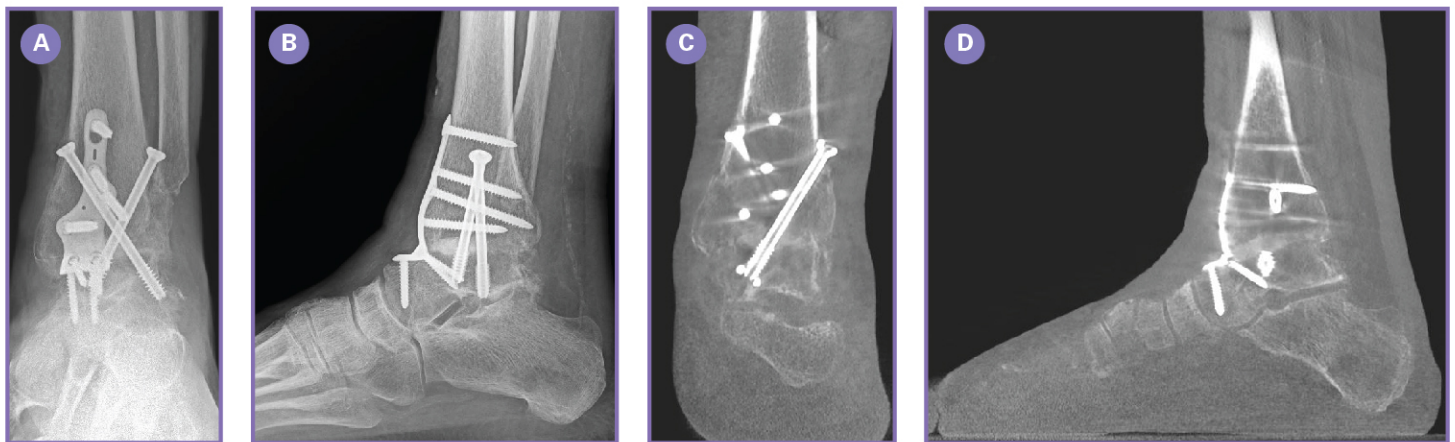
Weightbearing radiographs 10 weeks post-operative demonstrating mature fusion following anterior approach revision ankle fusion (A) AP and (B) Lateral. Weightbearing CT scan imaging confirming mature osseous integration 3 months post-operative at the ankle fusion site (C) Coronal and (D) Sagittal.
